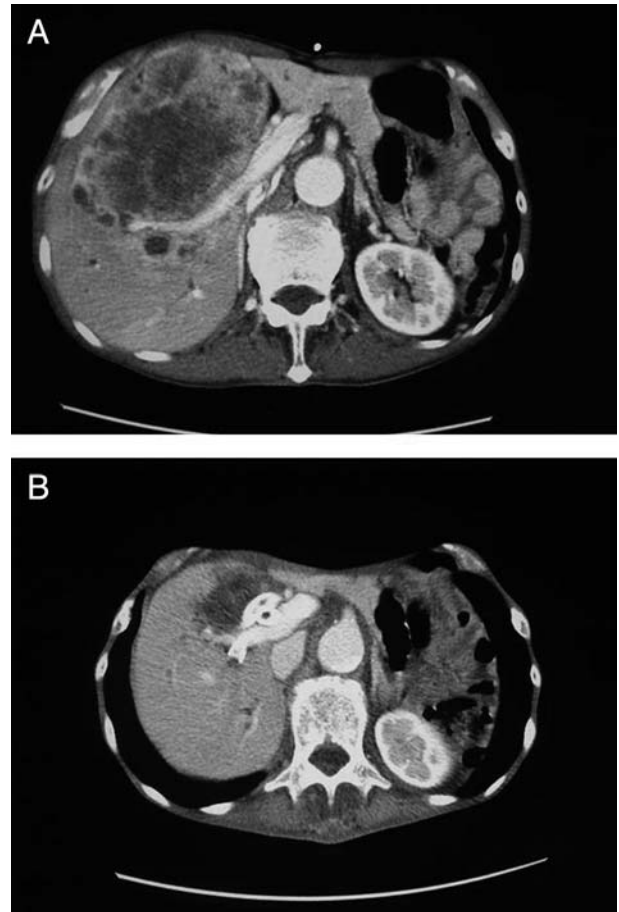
Benefit of cryosurgery. In all cases, not only did levels of serum tumor markers decrease, but local tumor necrosis was also observed. In addition to local changes of the treated area, tumor necrosis was identified away (B) from the treated area before treatment (A) on computed tomography.
